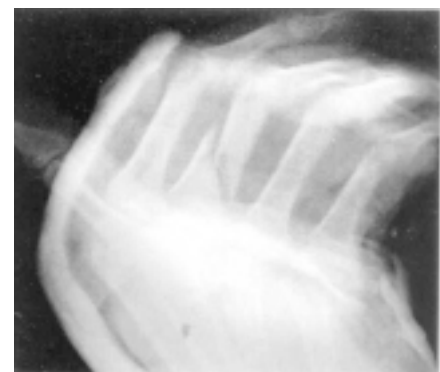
Radiograph showing loss of reduction
